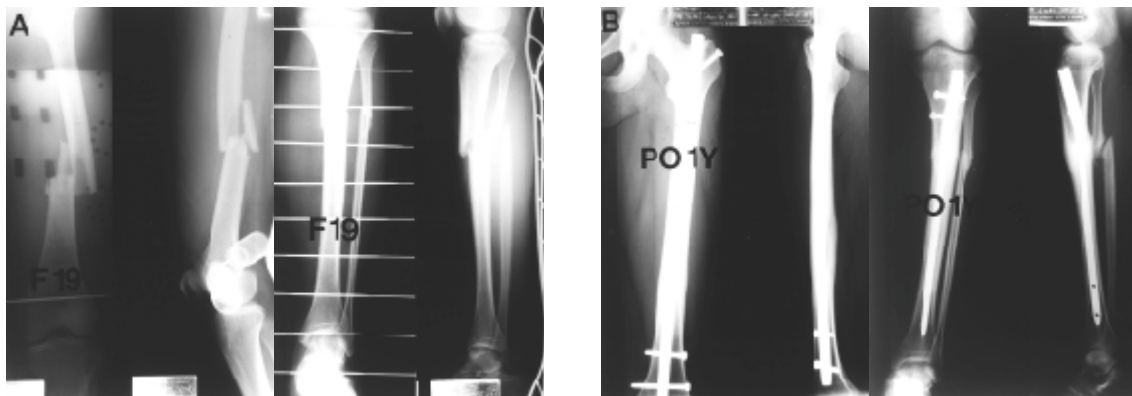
Preoperative radiographs of 19-year-old woman show comminuted femoral midshaft fracture and proximal one-third tibial fracture.
